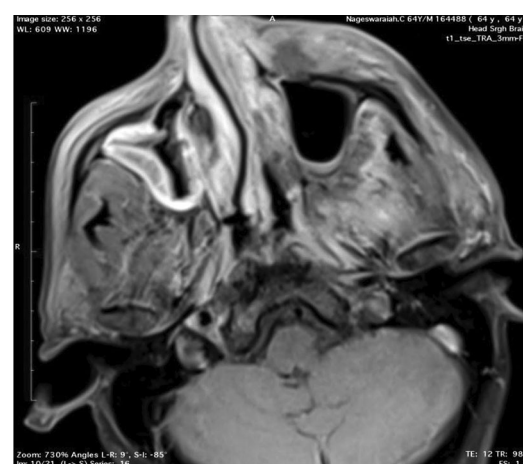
Axial CE T1 weighted MRI image in case of Mucormycosis showing left premaxillary and retro maxillary soft tissue swelling with mild enhancement .
